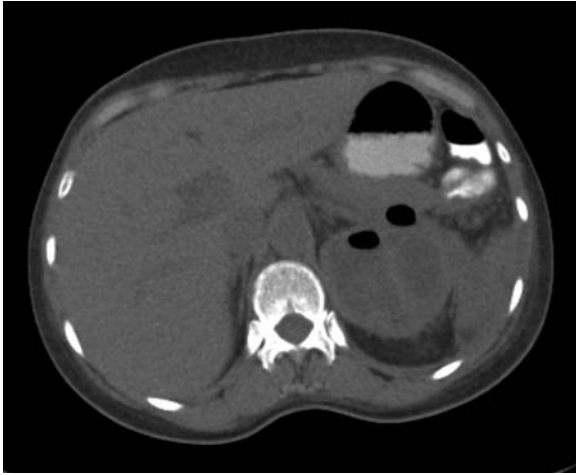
CT performed without intravenous contrast showing left-sided emphysematous pyelonephritis, with two discrete areas of gas within the renal parenchyma
